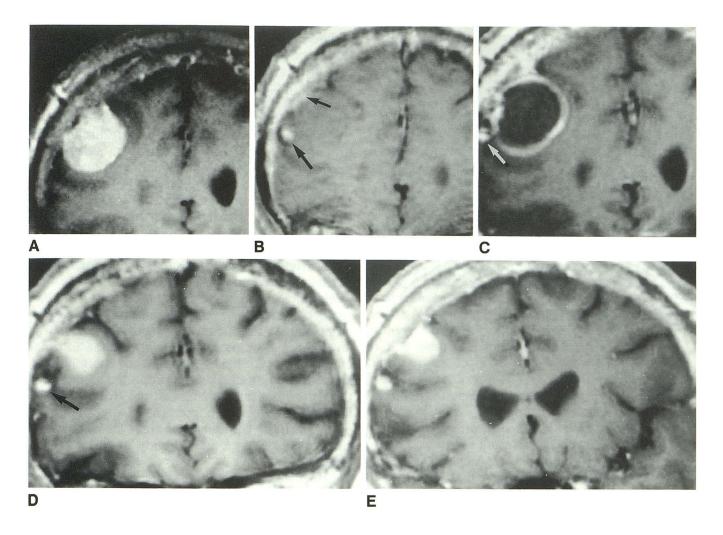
Microembolization of convexity meningioma with 50- to 150- $\mu$ m PVA particles (Table 2, case 13). A, Contrast-enhanced coronal 3-mm SE 500/20/2 MR image showing homogeneous tumor enhancement.
